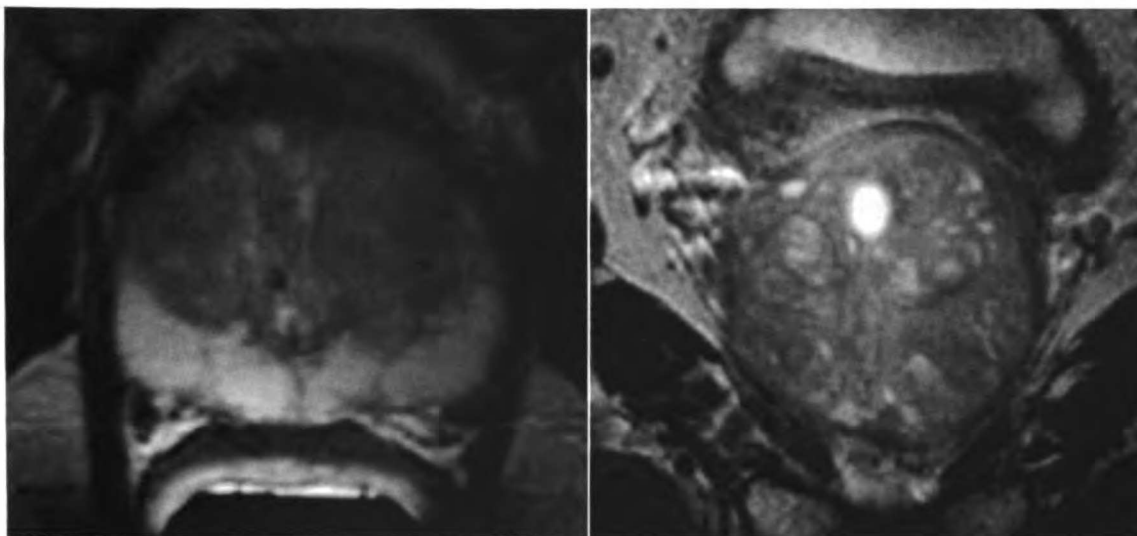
Oblique axial (left) and oblique coronal (right) T2-weighted FSE images acquired from a prostate cancer patient using the custom built single element endorectal coil. Excellent tissue contrast and SNR were obtained.
